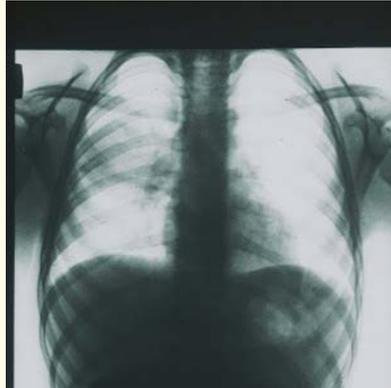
X-ray photograph of 2 y.o. girl 12 hours after the first signs of AP with abdominal pain syndrome were discovered. There is homogeneous shading in a middle-right pulmonary field.
